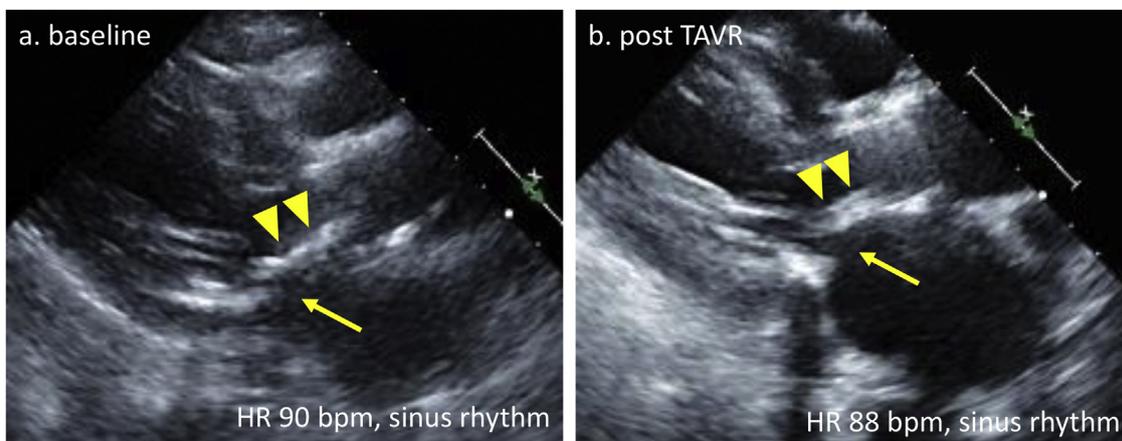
An example of patient 7 in which mitral leaflet mobility improved after TAVR. Parasternal long-axis view in the early diastole. Anterior mitral leaflet (arrow head) mobility severely reduced at baseline (a). It improved after TAVR (b). An increase in mitral orifice after TAVR was observed (arrow). HR, heart rate; TAVR, transcatheter aortic valve replacement.
